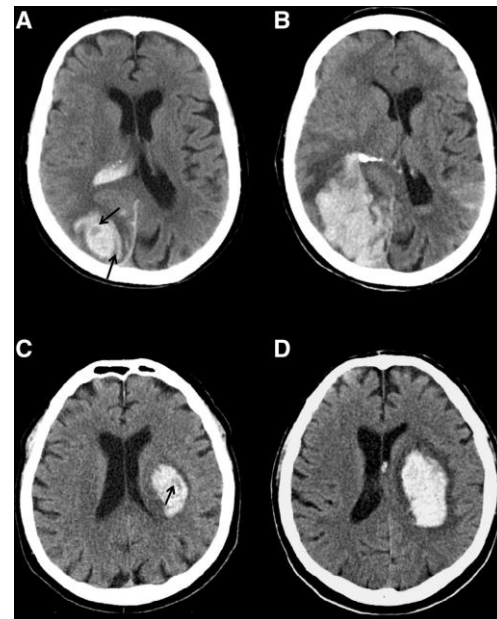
Noncontrast computed tomography (NCCT) hypodensities and hematoma expansion. A, Lobar intracerebral hemorrhage (ICH) with 29 mL baseline ICH volume and multiple hypodensities (black arrows). B, Follow-up NCCT showing hematoma expansion to 56 mL ICH volume. C, Deep ICH with 21 mL baseline ICH volume and intrahematoma hypodensity (black arrow). D, Follow-up NCCT showing hematoma expansion to 93 mL ICH volume.
